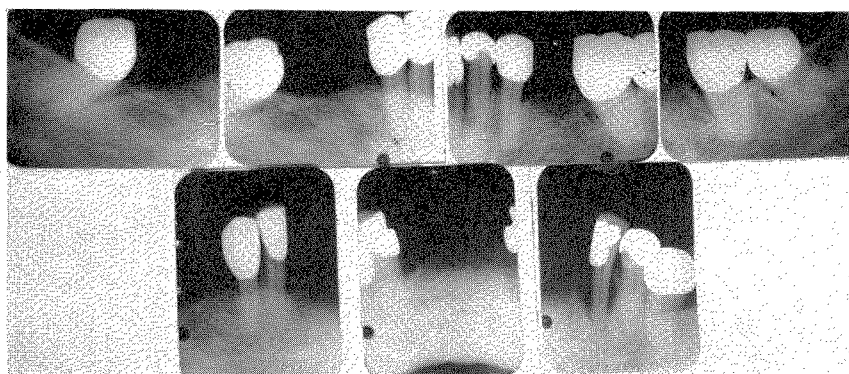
Roentgenograms taken in 1945. This was two years after completion. The alveolar bone structure already showed signs of periodontal involvement.
